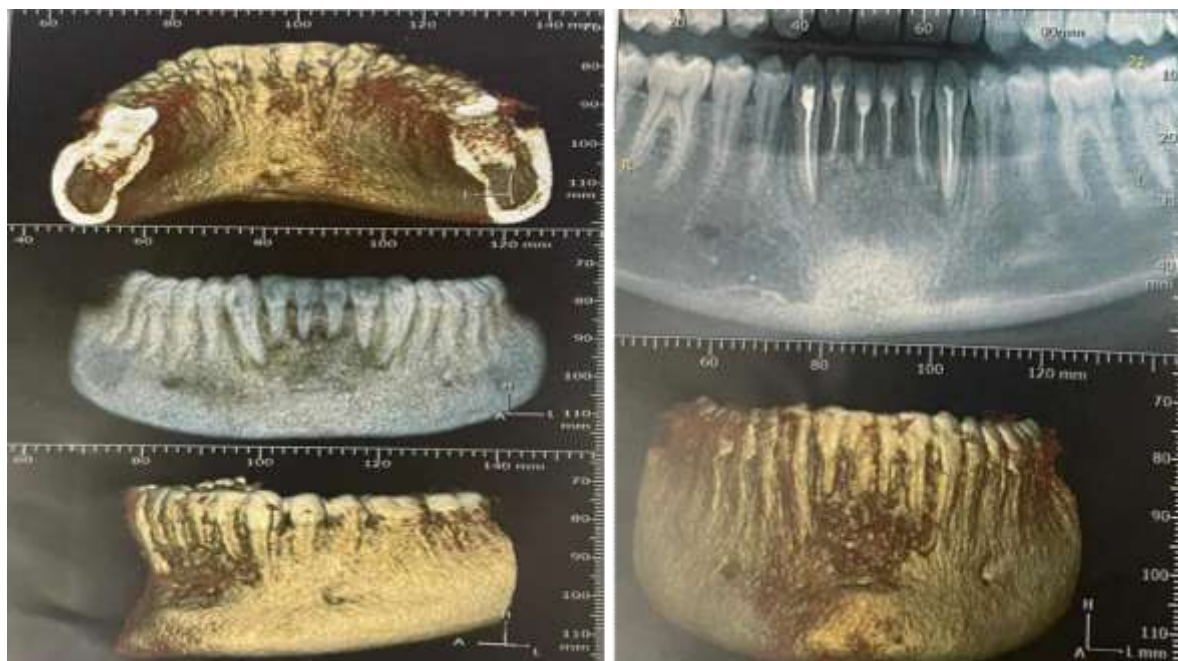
Cone beam computed tomography (CBCT) during follow-up.
